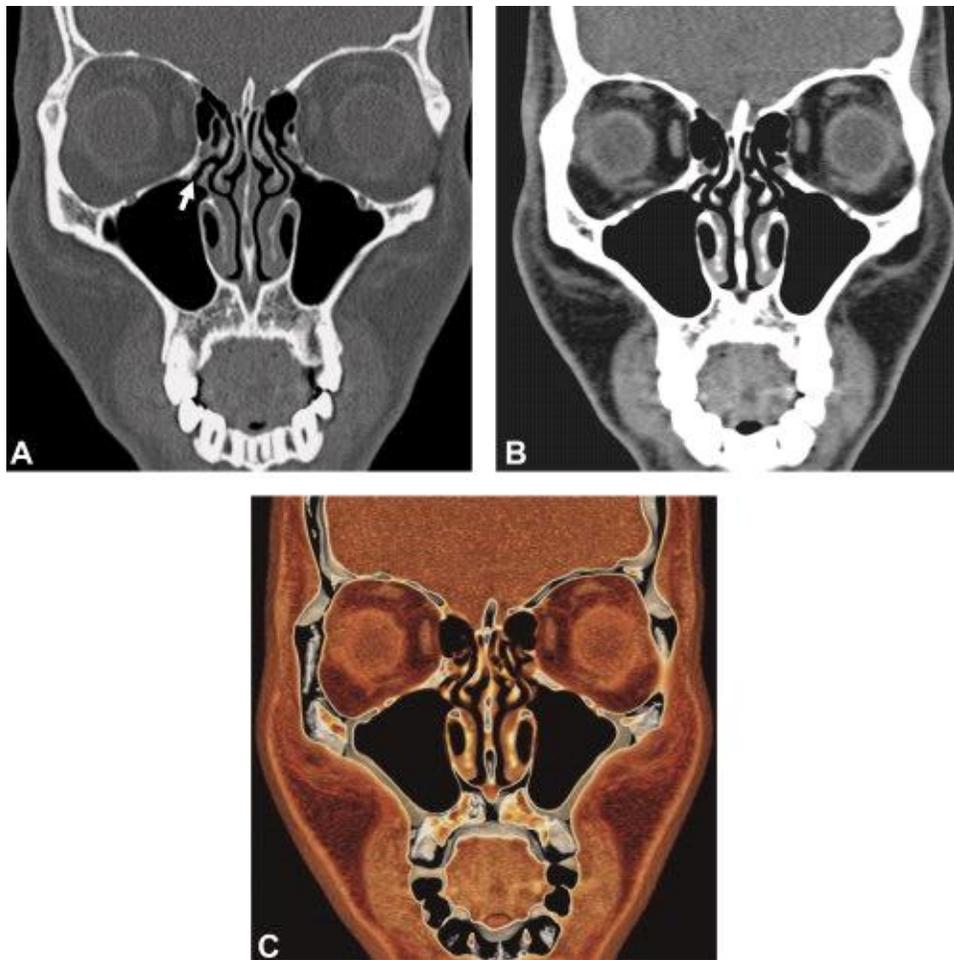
Coronal CT scans of the paranasal sinuses at the level of the alveolar recess of the maxilla, (A) bone algorithm, (B) soft-tissue algorithm, and (C) 3D constructions demonstrating the importance of visualizing scans in the coronal plane. Certain structures, including important
